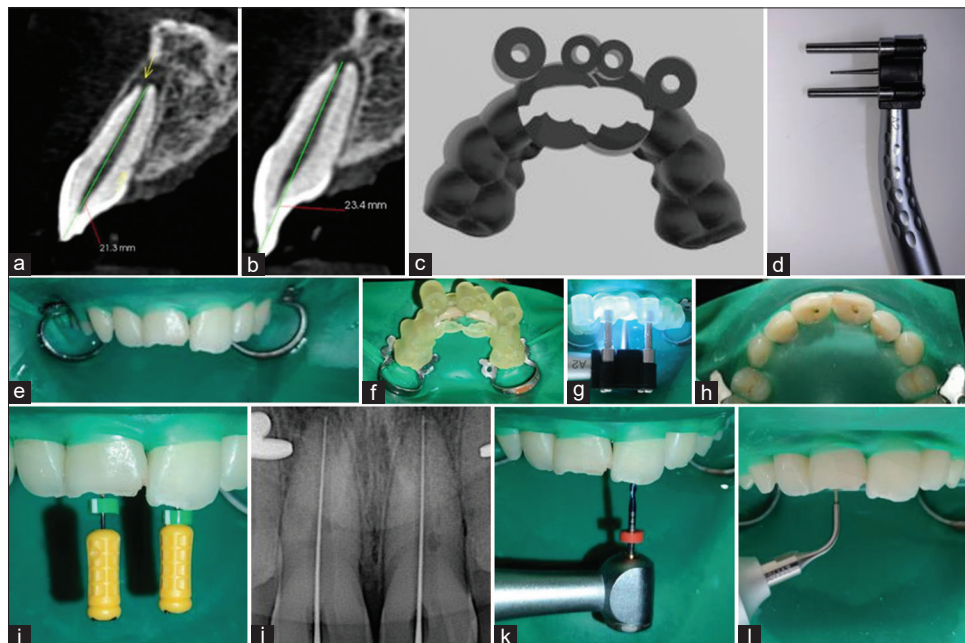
(a) Preoperative cone-beam computed tomography (CBCT) showing open apex to 11, (b) Preoperative CBCT showing open apex to 21, (c) Customised sleeveless guide, (d) PriciGuide™ system, (e) Isolation under rubber dam, (f) Guide placed on the teeth, (g) PriciGuide™ system used to perform access opening, (h) Guided access opening, (i and j) Working length determination, (k) Cleaning and shaping using reciprocating files, (l) Passive ultrasonic activation using UltraX
